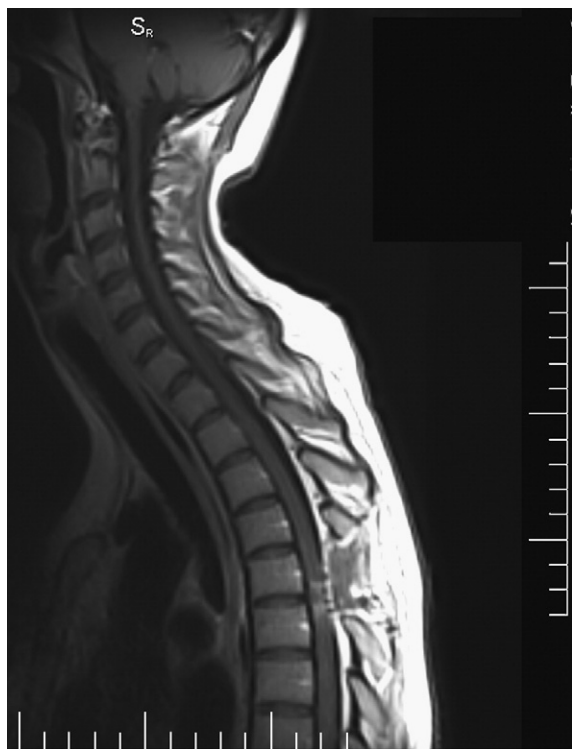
Sagittal MR imaging of a patient taken one week after MSCs implantation.
